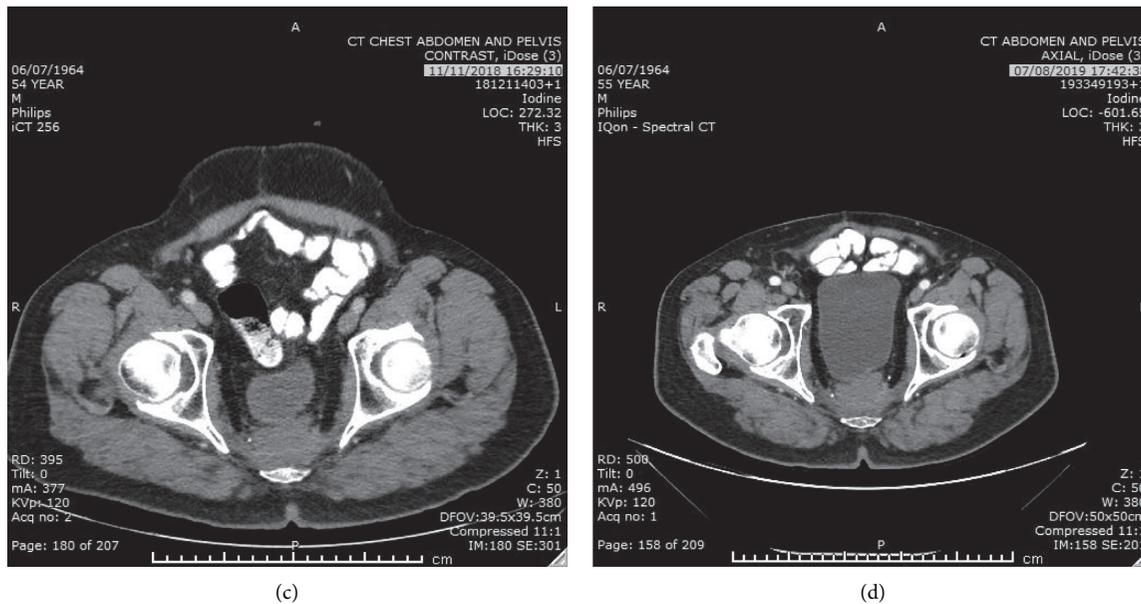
Stability of presacral CRC metastatic lesion on PARP inhibitor therapy. Axial computed tomography scans during treatment are provided: (a) July 2017, (b) April 2018, (c) November 2018, and (d) August 2019.
